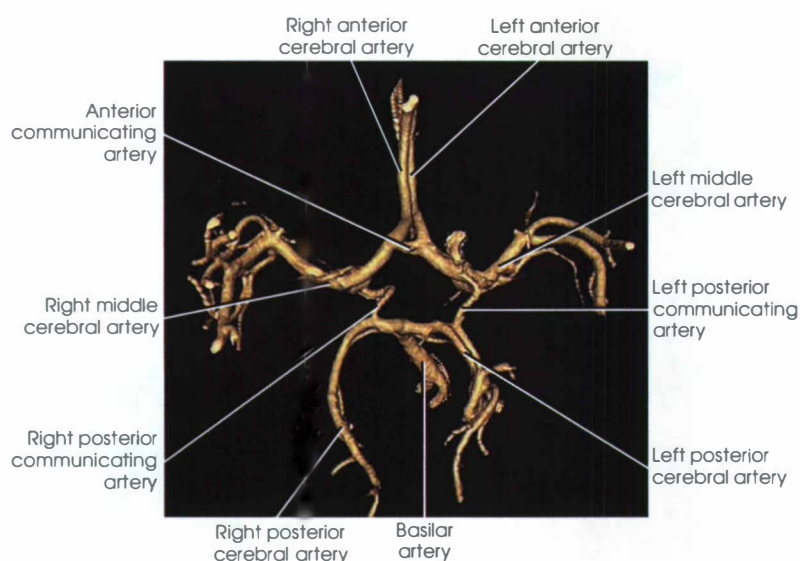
Color CT angiography of the circle of Willis.
